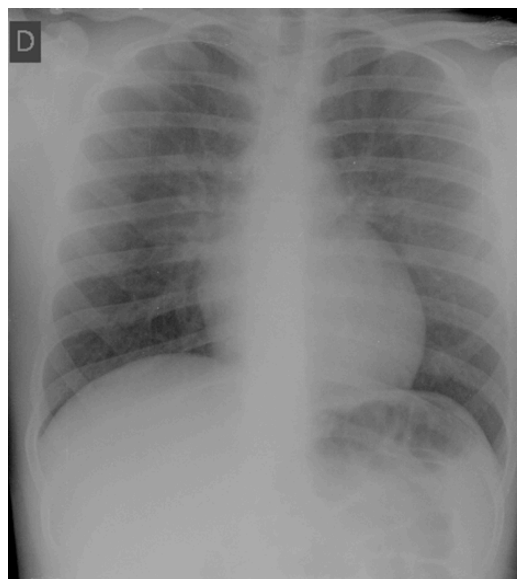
Antero-posterior chest radiograph hours after starting intravenous furosemide and supplementary oxygen administration, showing reduction of bilateral diffuse opacities
